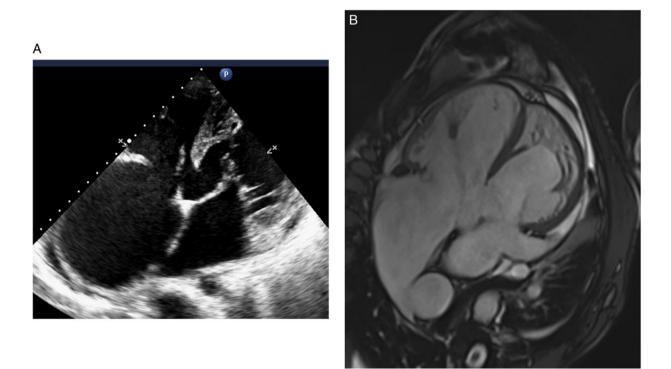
Transthoracic echocardiogram (A) and cardiac magnetic resonance imaging (B) of a patient with diagnosis of congenitally corrected transposition of the great arteries and large ventricular septal defect in destrocardia.
